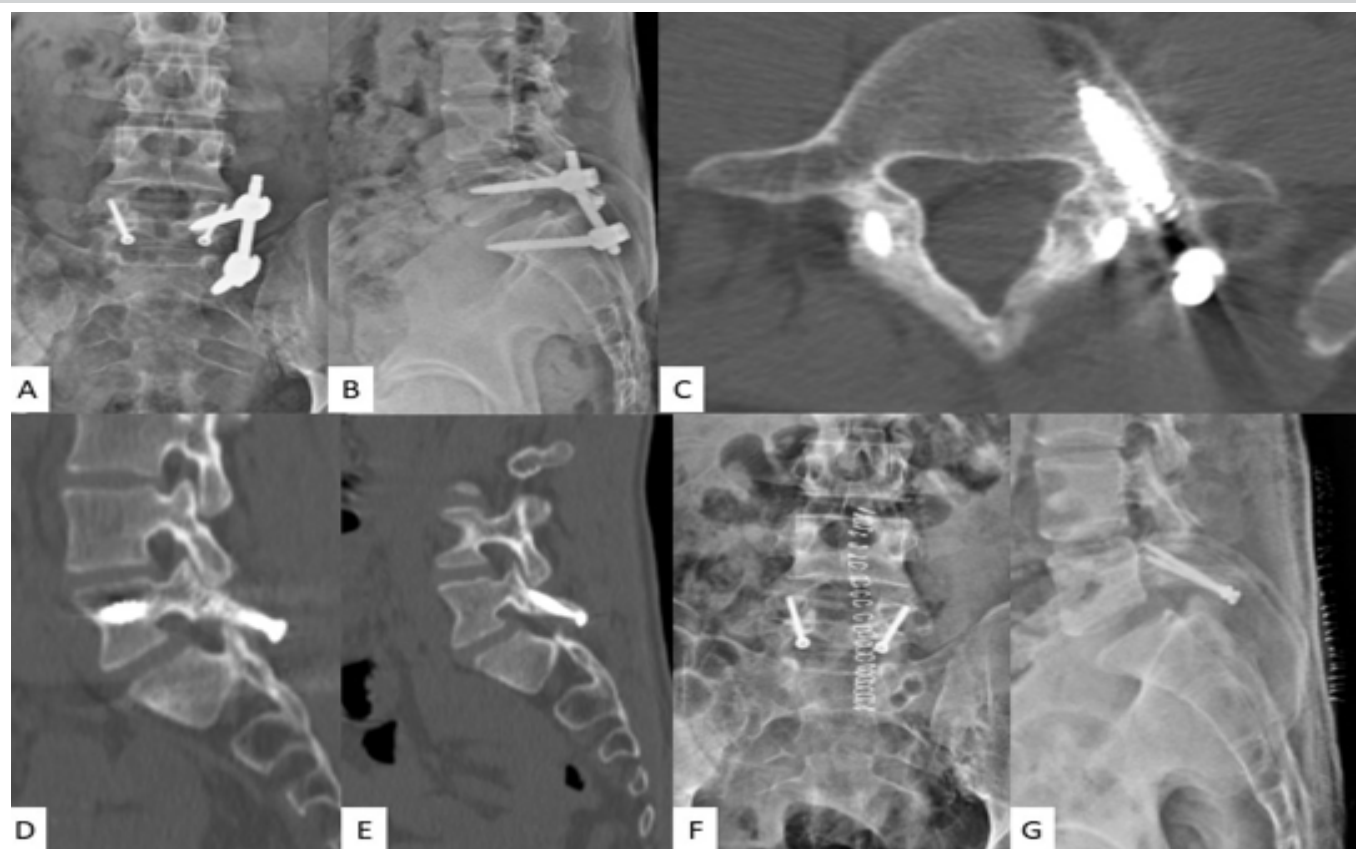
Final follow-up (24 months) images. (a and b) Anteroposterior (AP) and lateral plain radiographs showing satisfactory position of the implants. (c, d and e) Computed tomography images showing axial, right parasagittal and left parasagittal sections indicating excellent healing of the of pars defect. (f and g) AP and lateral plain lumbar radiographs after temporary pedicle screw-rod construct removal.
